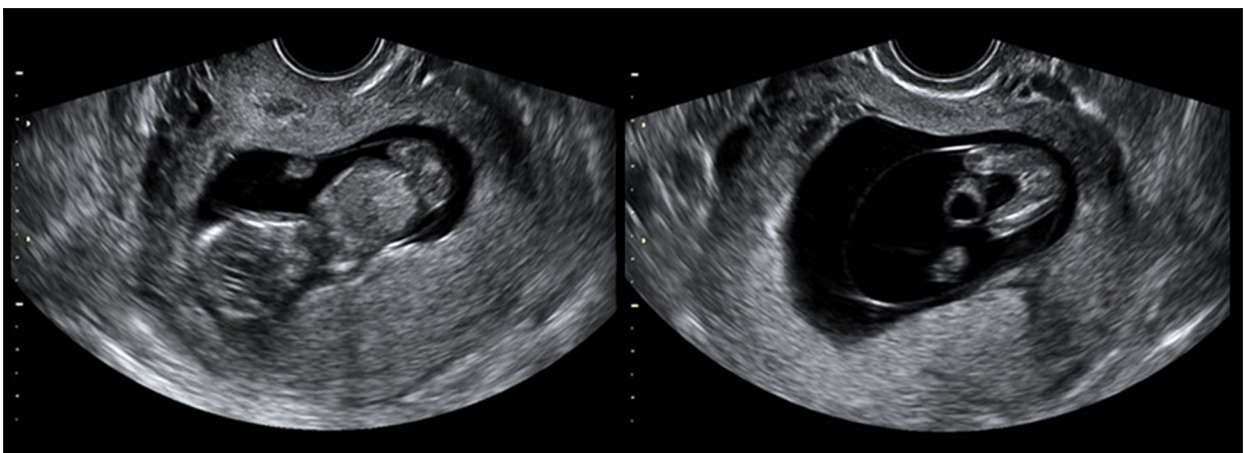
Fetal ultrasonography at 12 weeks and 4 days of gestation age. There was a cystic lesion at the fetal umbilical region.
